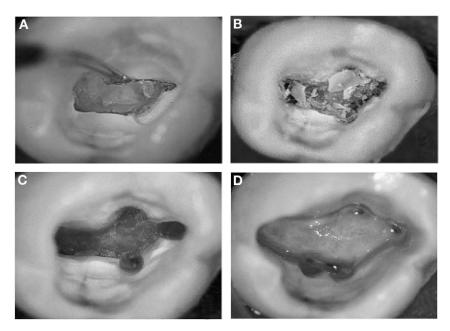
(A) An ultrasonic tip is being used to remove heavy calcific deposits on the floor of a maxillary molar pulp chamber. (B) The use of ultrasonic energy led to shattering of pulp stone. (C) This picture reveals the presence of four root canal orifices, but the absence of any pulpal floor road map. (D) Continued removal of calcification and refinement of access cavity with ultrasonic instruments exposes the floor of the pulp chamber and the presence of an additional distobuccal canal. (Courtesy of Dr. Helmut Walsch, Munich, Germany.)
